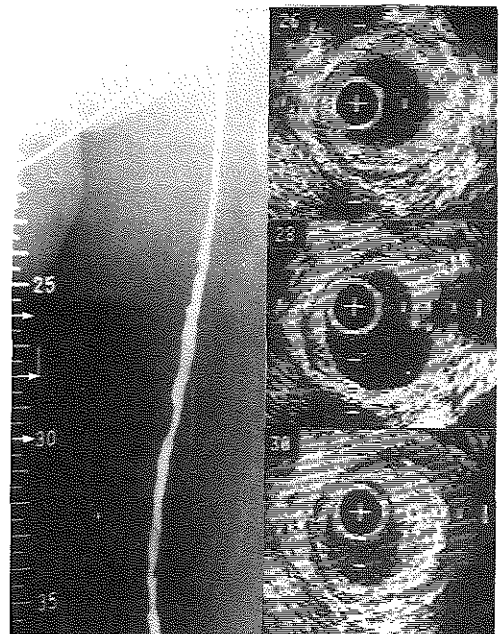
Intravascular ultrasound cross sections and the corresponding angiogram of the superficial femoral artery obtained before intervention. Proximally at level 26, a concentric soft lesion distributes along the entire circumference of the vessel wall. Distally at level 28, an eccentric hard lesion is visualized causing ultrasonic shadowing at 3 o'clock. Level 30 shows an eccentric lesion predominantly involving one segment of the vessel wall. At the outer perimeter of the lesion adjacent to the media at 3 o'clock an intense echoreflection is seen interpreted as calcium. Calibration=1 mm.
